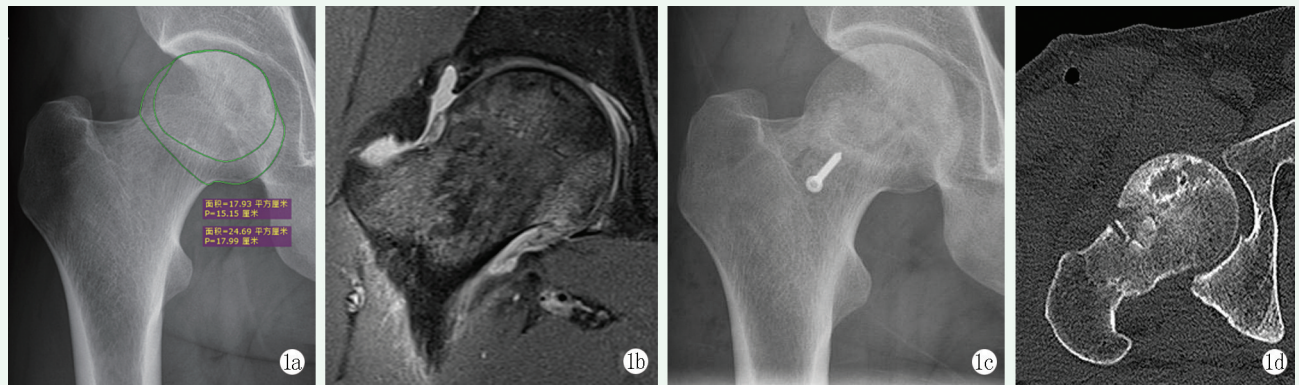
患者男性, 40 岁。1a: 术前骨盆正位 X 线片示右侧股骨头坏死, 未见股骨头塌陷, Tönnis 分级 0 级; 1b: 术前 MRI 可见 T2 像下股骨头坏死区域呈混杂信号改变, 符合 ARCO IIC 期; 1c: 开窗植骨术后末次随访 X 线片见螺钉位置良好, 无断裂、移位; 1d: 末次随访 CT 可见股骨头形状圆滑无塌陷。
